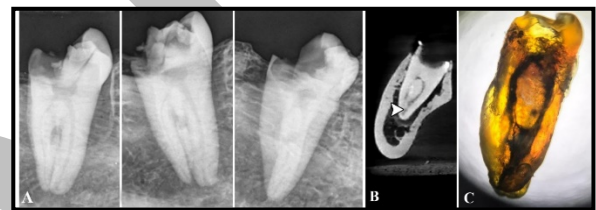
images (B) and (C) show matching between CBCT and clearing technique in detection of confluent canals while image (A) taken from different angulations shows that Digital periapical radiograph can't detect the presence of confluent canals.
